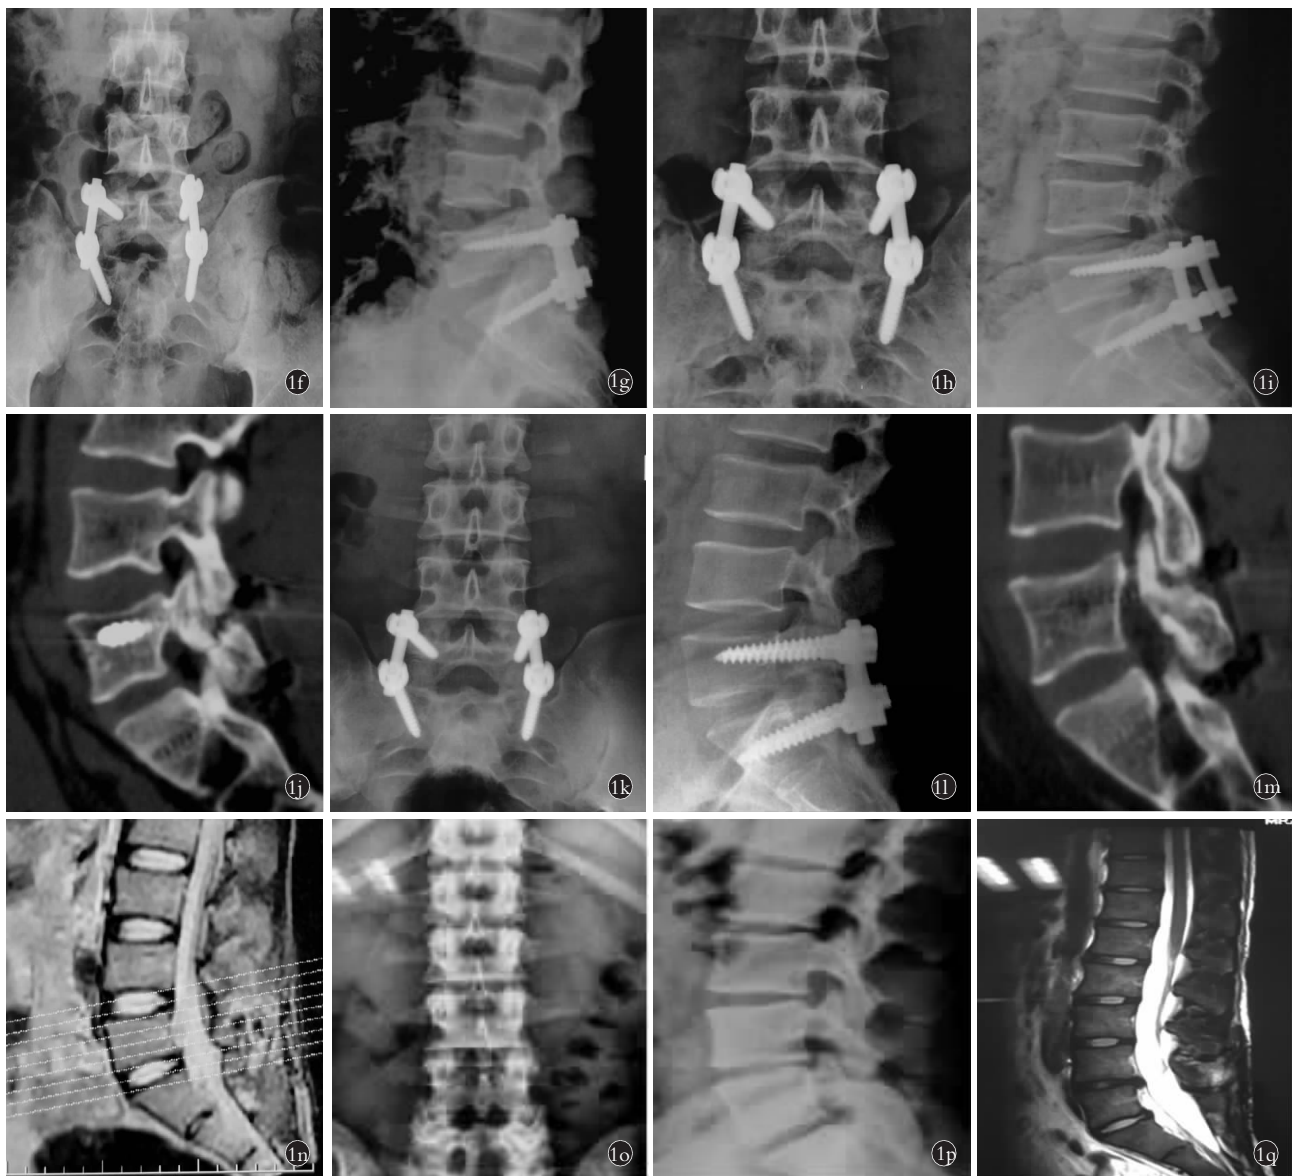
患者,男,18 岁,L₅ 峡部裂,腰椎无滑脱 1f. 术后 1 周正位 X 线片见内固定在位良好 1g. 术后 1 周侧位 X 线片见内固定在位良好 1h. 术后 6 个月正位 X 线片见内固定在位良好,螺钉无松动 1i. 术后 6 个月侧位 X 线片见内固定在位良好,螺钉无松动 1j. 术后 6 个月腰椎 CT 重建见峡部未完全融合 1k. 术后 12 个月腰椎正位 X 线片见内固定在位良好,螺钉无松动 1l. 术后 12 个月腰椎侧位 X 线片见内固定在位良好,螺钉无松动 1m. 术后 12 个月腰椎 CT 重建见峡部完全融合 1n. 术后 12 个月腰椎 MRI 无病变节段及相邻节段退变 1o. 术后 8 年,内固定已去除,腰椎稳定,序列正常 1p. 术后 8 年,内固定已去除,序列正常,无退变及峡部再发骨折 1q. 术后 8 年,腰椎 MRI 见 L₅S₁ 间盘信号正常
